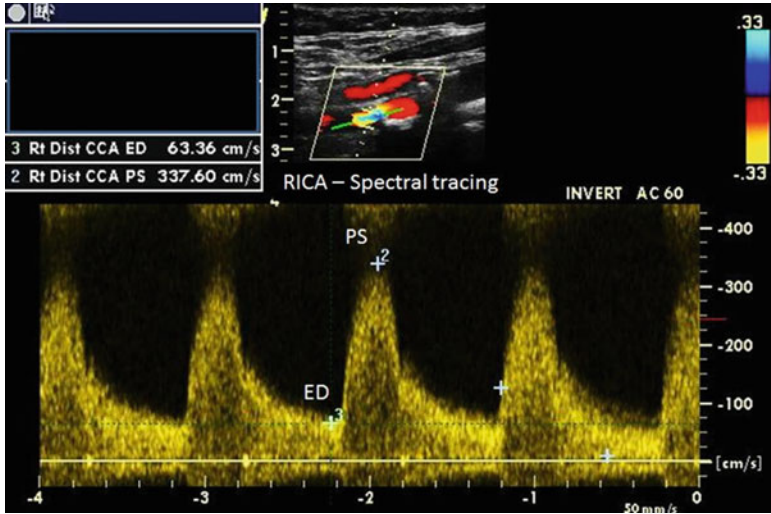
Doppler imaging showing increased velocity just beyond the stenosis in the right internal carotid artery (RICA) The peak systolic velocity is 337.60 cm/s (compare to the less than 150 cm/s from the normal depicted in Fig. 3.16)
